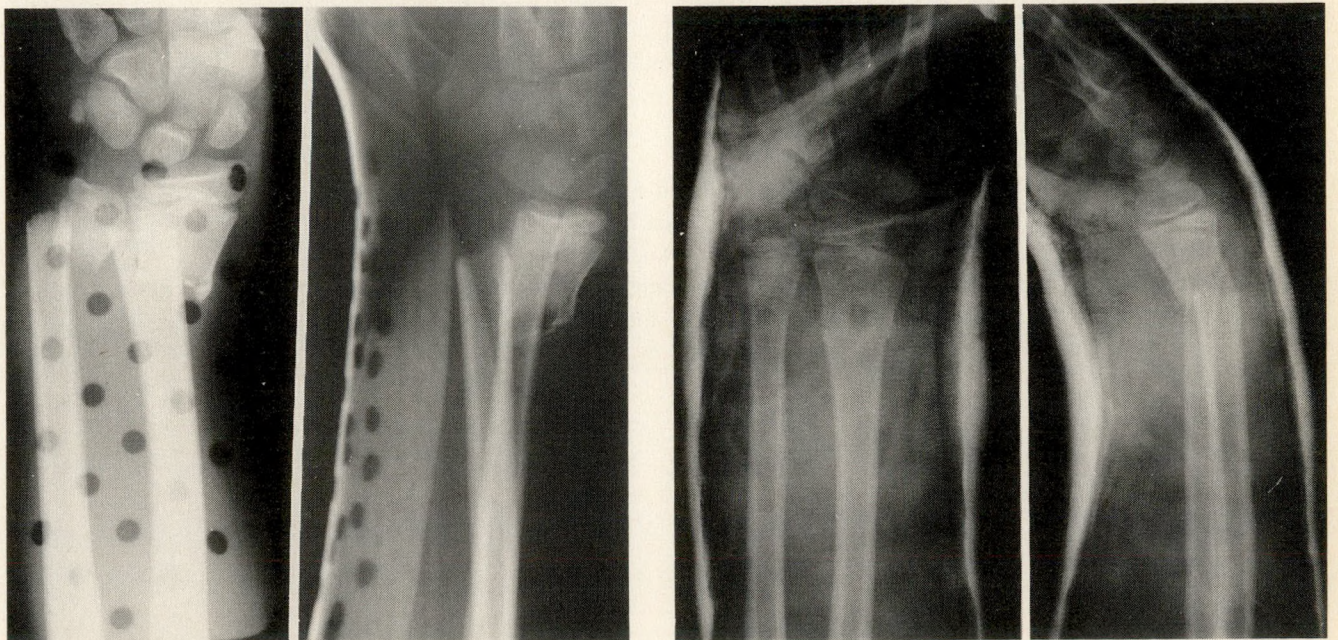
(Left) Prereduction radiographs of forearm fracture in 8-year old boy. Note complete displacement of fracture fragments. (Right) Same extremity after satisfactory reduction and casting under intravenous regional anesthesia.
